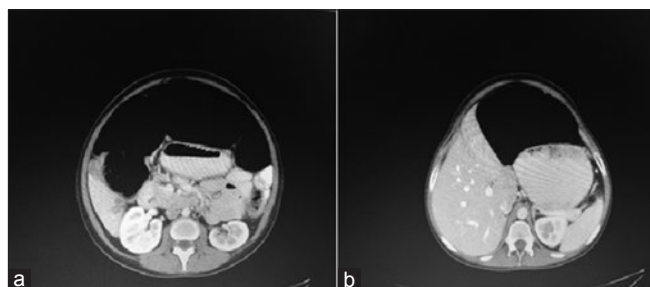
(a-b) Follow-up computed tomography scan revealed a decrease in the size of the liver abscess and complete resolving of the wall thickness of the colon
